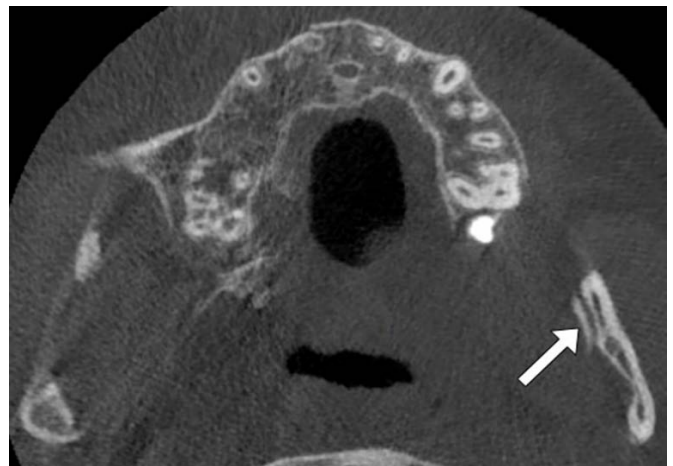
Axial CBCT image of TCC
